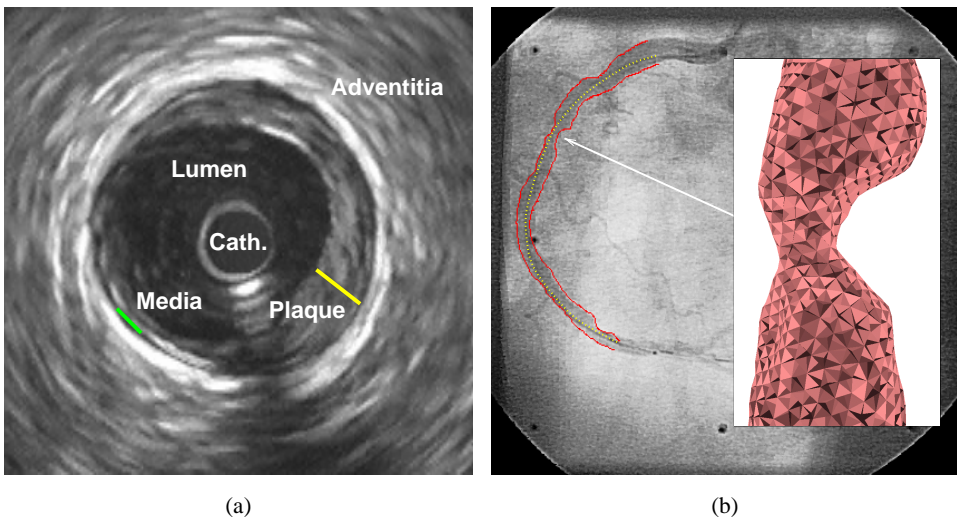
(a) example of an intravascular-ultrasound image; the layers are clearly visible, along with some eccentric plaque; (b) extraction of the IVUS catheter path (dotted line) and the lumen from one of the angiograms, the inset shows the tetrahedral mesh of the lumen after 3-D fusion.
